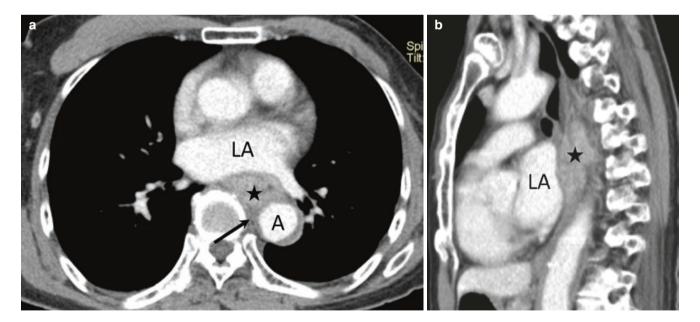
Pericardium and aortic involvement by esophageal cancer. (a, b) Axial and sagittal CT images show mid-esophageal mass (asterisk) indenting the left atrium. Although the mass is in contact with less
